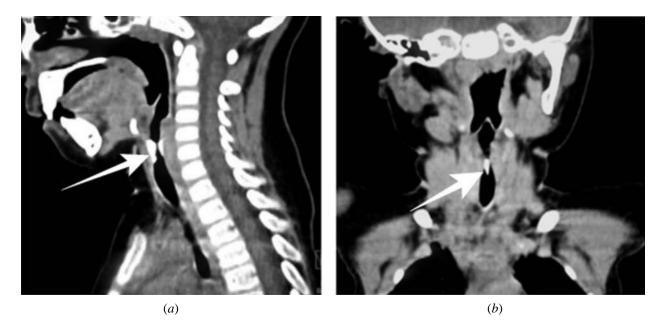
Conrast enhanced computed tomogram of the cervical Sagittal (a), and Coronal (b) multiplanar reconstruction of images reveal high density elongated structure with sharp inferior tip lodged in airway (thick arrow) straddling across its lumen, causing luminal narrowing (arrowheads).
